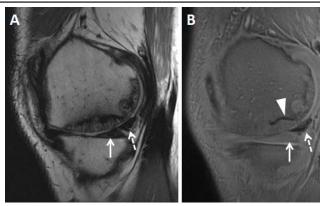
37 year-old man with hemophilic arthropathy of the knee. (A) Conventional intermediate-weighted sagittal MR image (TR 2600 ms, TE 40 ms) shows no distinction between meniscus (arrow) and hypertrophic hemosiderin-laden synovium (dashed arrow), both appearing dark with near-zero signal. (B) Improved contrast with UTE MRI (TE 0.03 ms) allows distinction between meniscus (arrow) and synovium (dashed arrow). Additional foci of hemosiderin deposition are seen lining a subchondral cyst (arrowhead) as well as in the medial gutter and posterior recesses.
